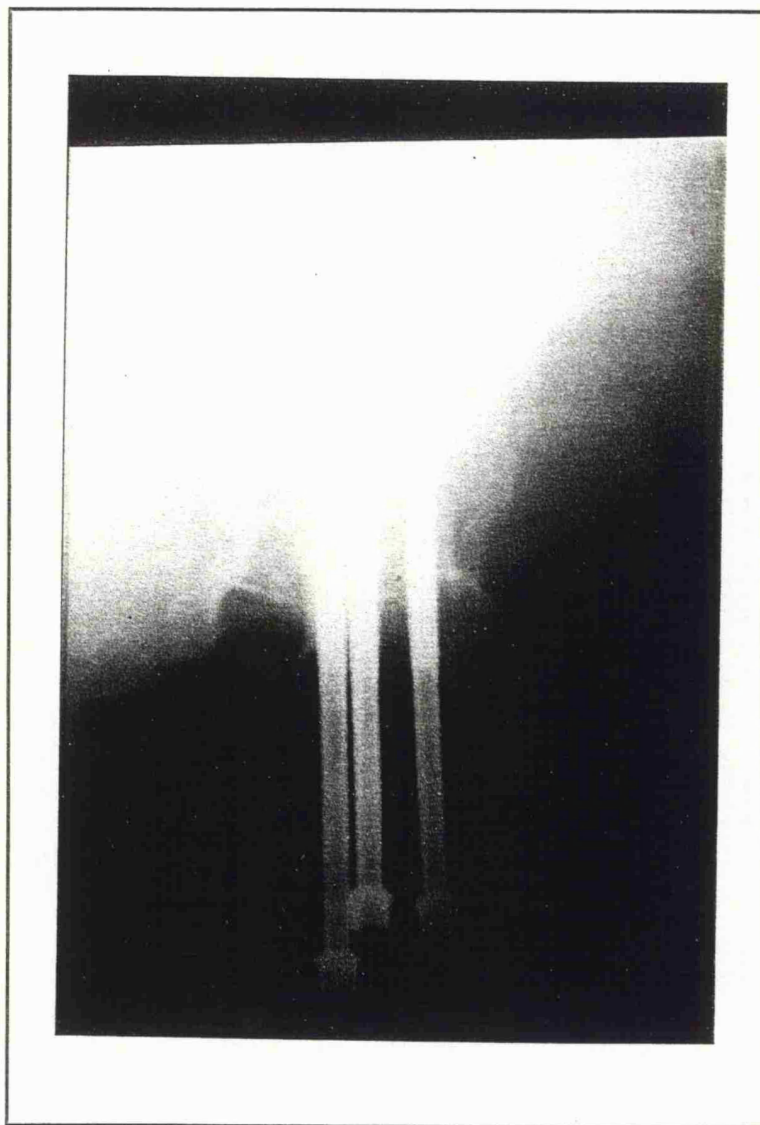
Antero-posterior radiograph showing position of cannulated hip screws.
